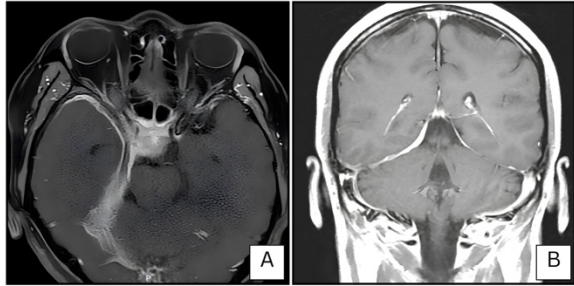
Interval decrease in hyperintensity of the right tentorium and anterior temporal lobe on contrast MRI.
